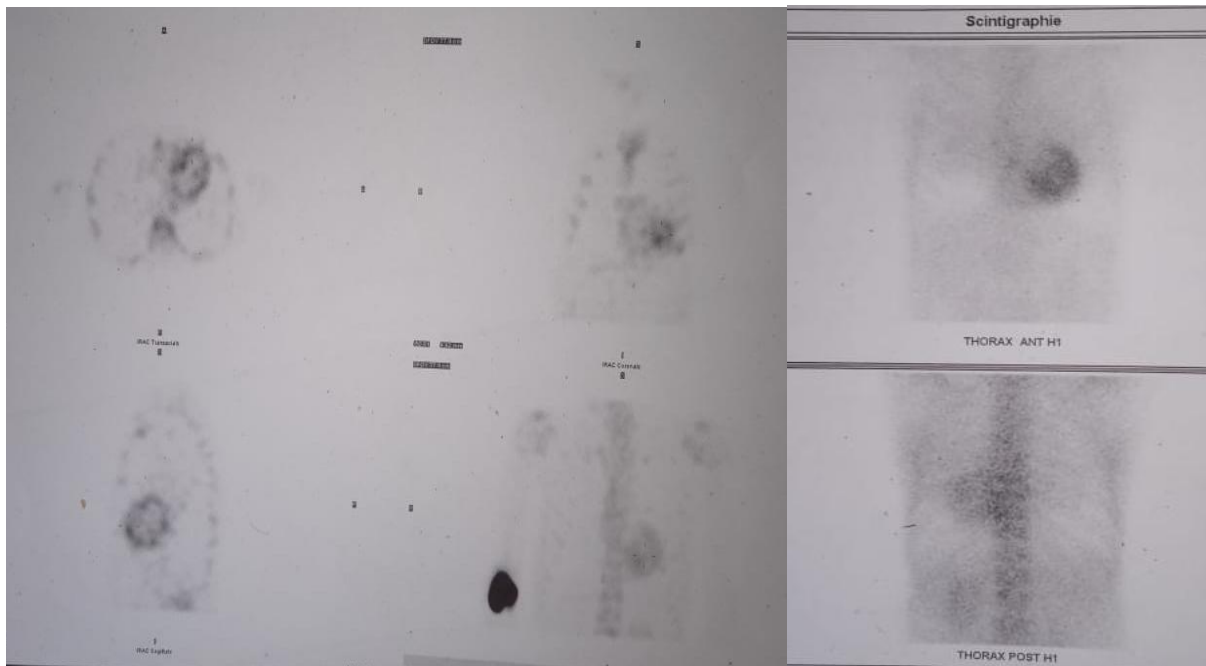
Tc-Pyrophosphate scintigraphy proving a grade 3 uptake
